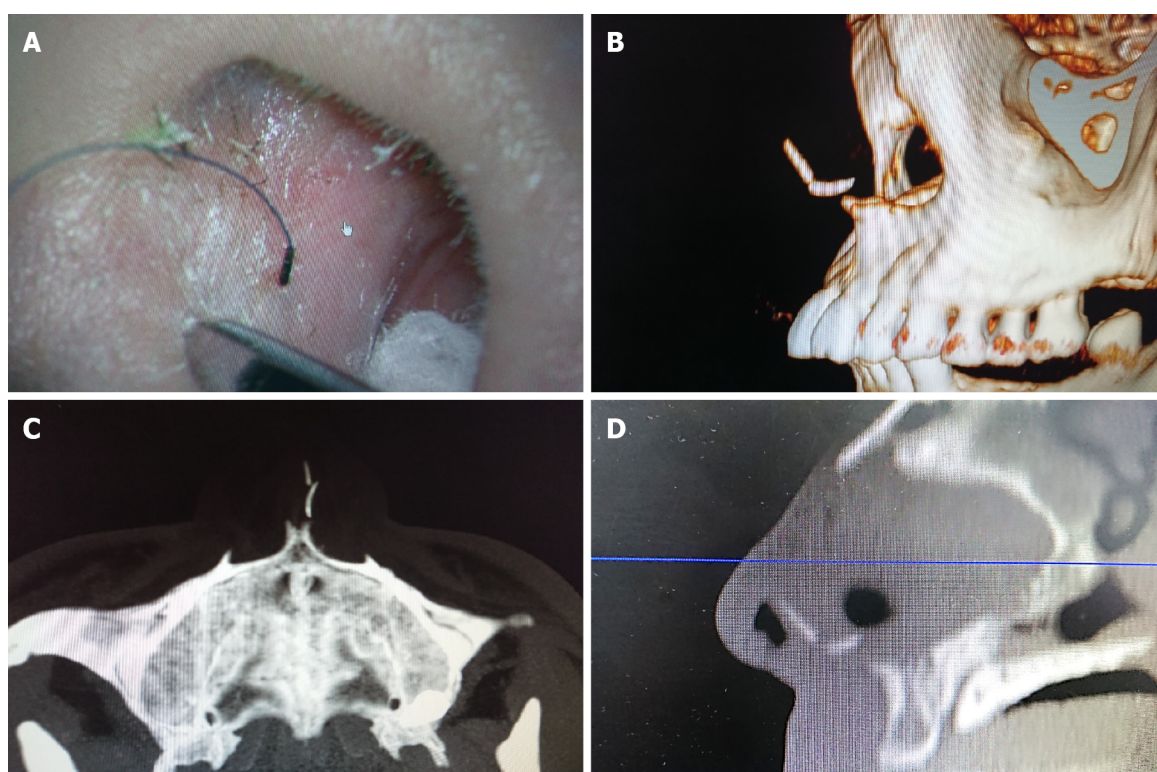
Computed tomography scan of the nasal sinuses after the third surgery. A: A needle was used as a reference; B: Three-dimensional reconstruction; C and D: Axial (C) and sagittal planes (D) showing that the needle was pointing right to the pin-like foreign body.
